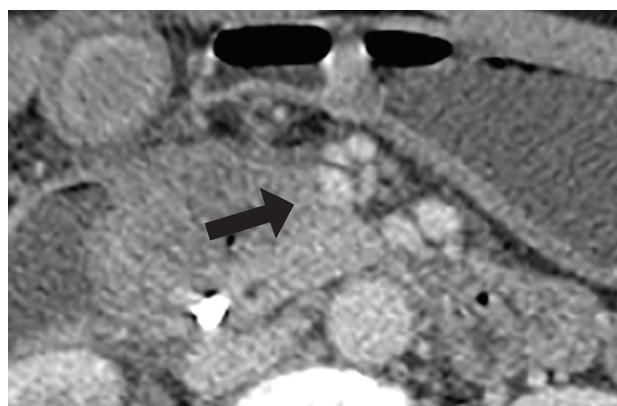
CT images of T2 disease Our case of T3 stage disease; contrast enhanced CT image, axial plane, venous phase; hypodense mass in the head of the pancreas abutting the superior mesenteric vein (arrow); no narrowing of the vessel is seen.
